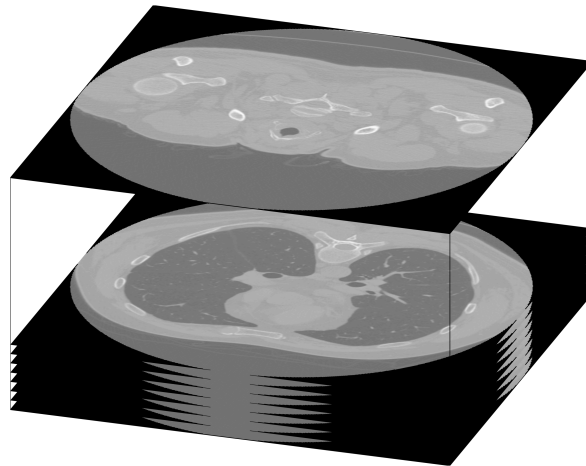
Three-dimensional CT image of the thorax created by stacking individual two-dimensional axial slices. Figure created using a control patient from the COPDGene study [166].
